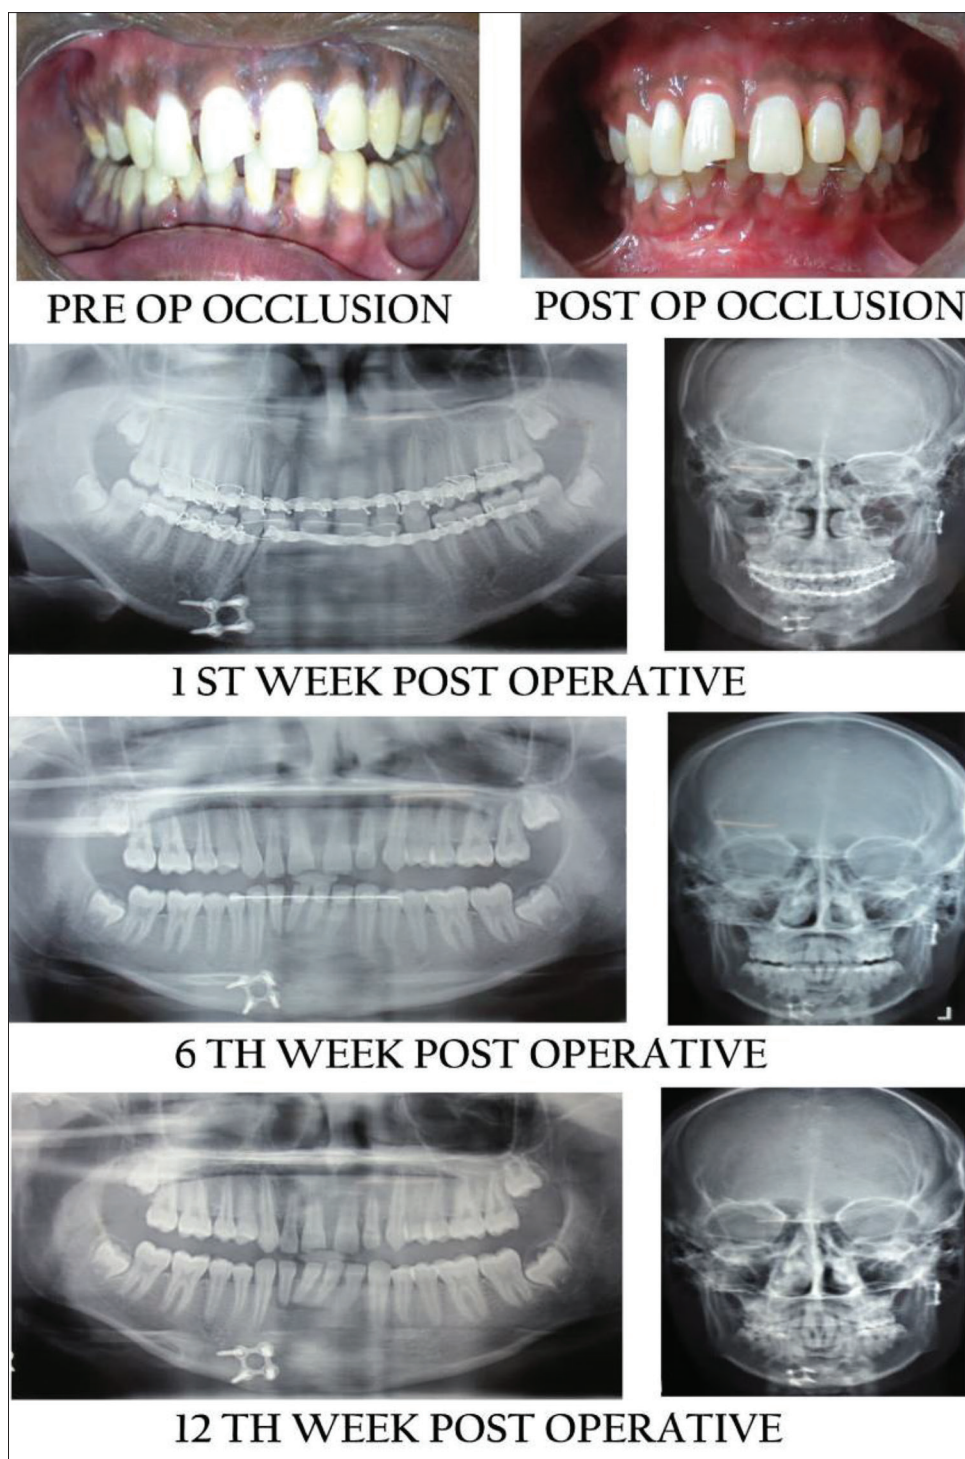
The post-operative occlusion and radiographic fracture healing after the placement of three-dimensional locking plate at 1st, 6th, and 12th weeks postoperatively
